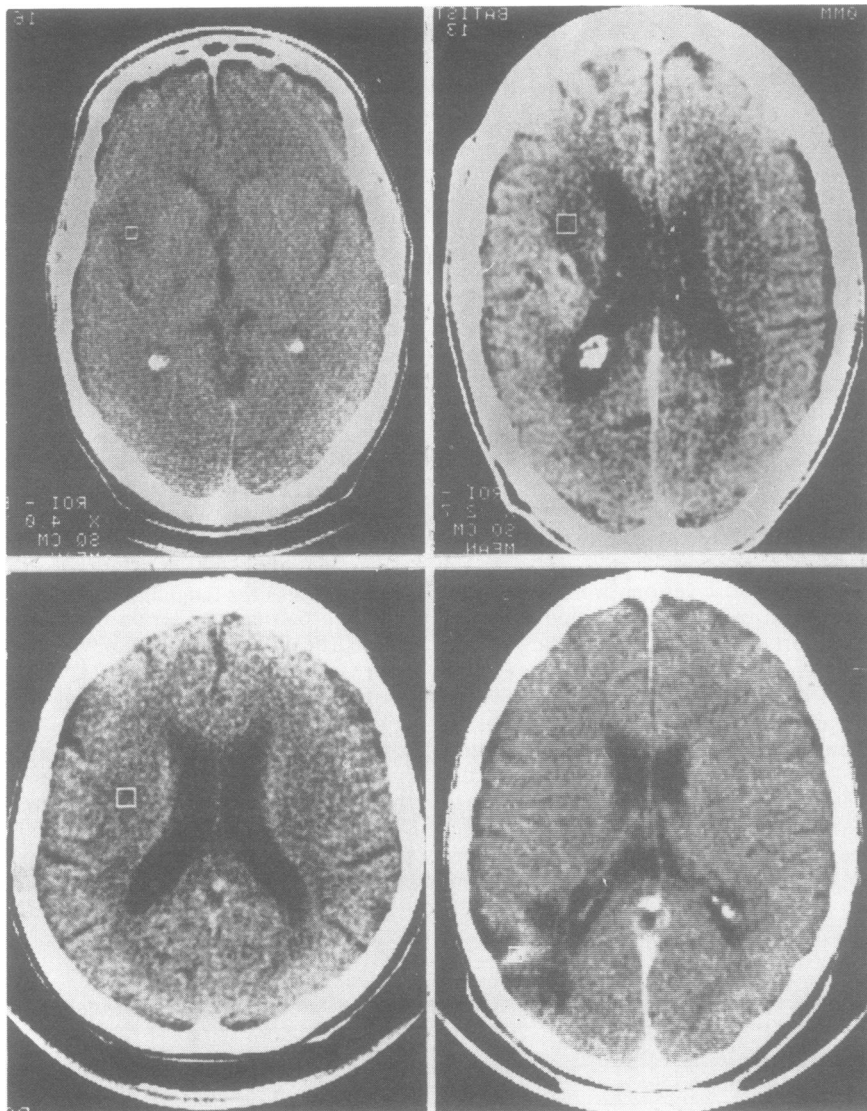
CT scans of 4 patients who were severely impaired on Gesture Recognition Test, but had good aural comprehension.
